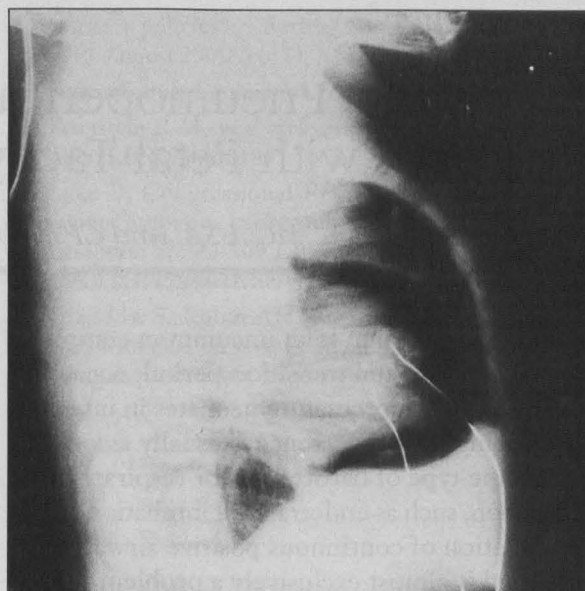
Initial chest radiograph showing pericardial air anteriorly.
